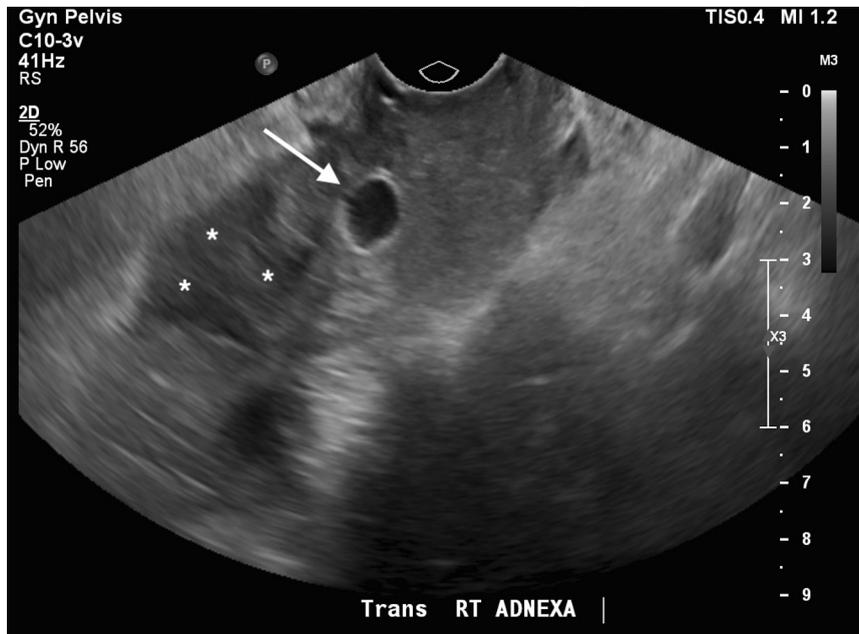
Transvaginal ultrasound with * denoting heterogeneous fluid collection near the right adnexa consistent with blood products and arrow pointing to the pseudoaneurysm.
